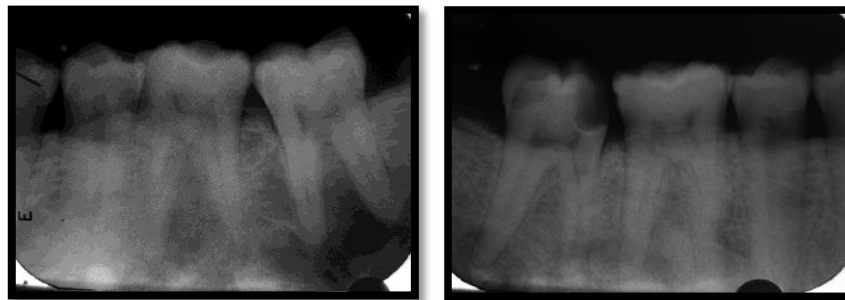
Intra Oral Periapical Radiographs Showing Multiple Mixed Radiolucent-Radiopaque Lesions Corresponding to the Periapical Areas of the Teeth with Intact Lamina Dura, at a Level Above the Inferior Alveolar Canal.
